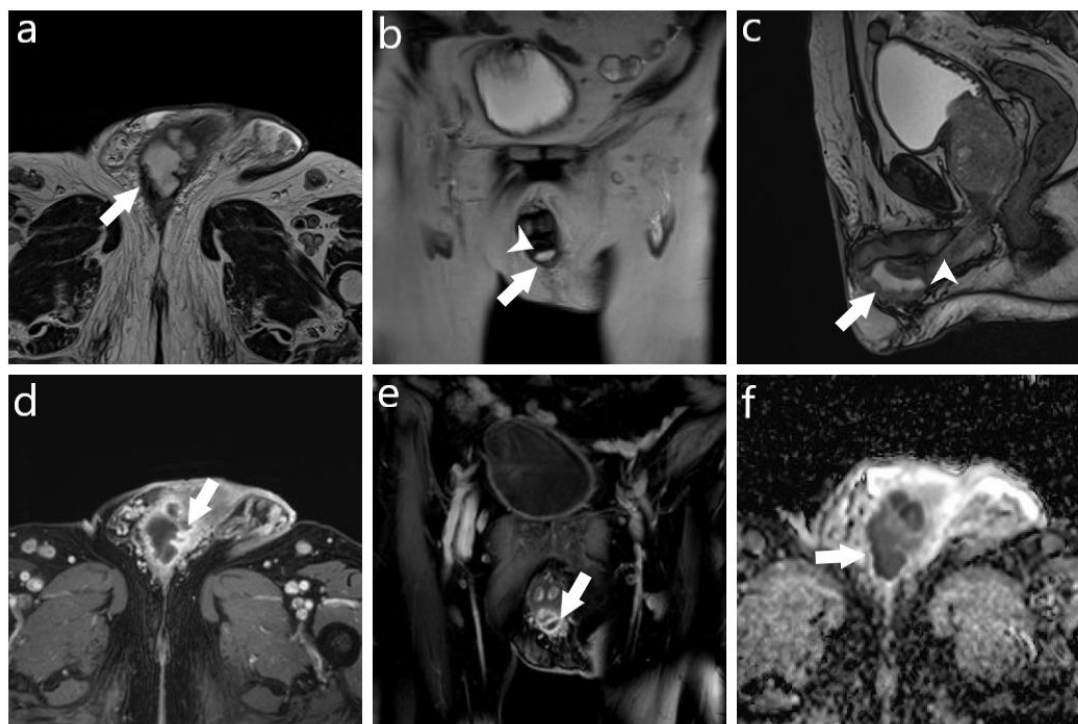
Magnetic resonance imaging (MRI) findings of corpus spongiosum abscess
